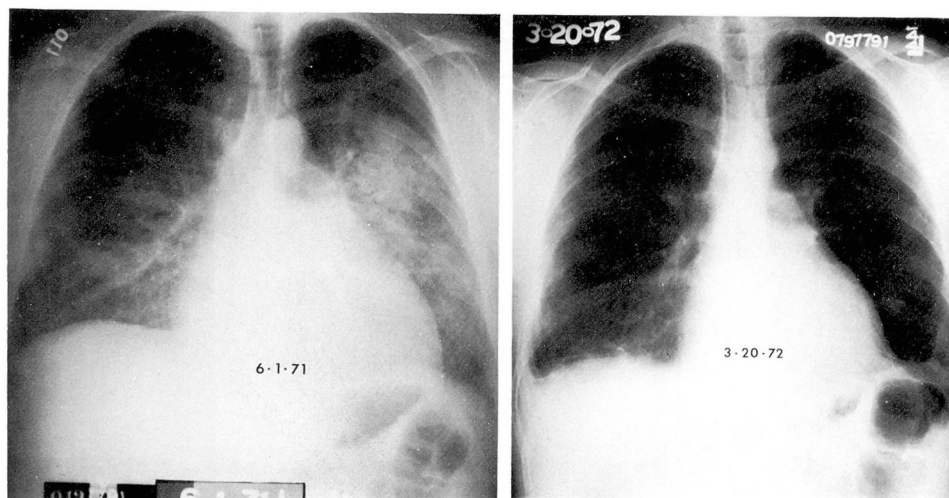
The chest roentgenogram of a 31-year-old butcher showing marked cardiac enlargement and congestive changes (6-1-71), and resolution of these findings after treatment with sulfadiazine-pyrimethamine (3-20-72) (case 2). (Courtesy of Wolf F. C. Duvernoy, M.D.; to be published as a case report.)
